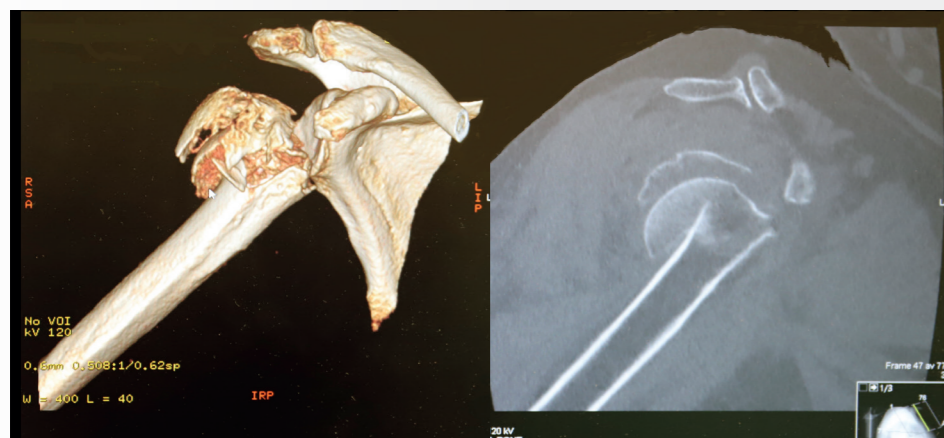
pre-op CT scanner 3D rendering (left) and sagittal view (right) of proximal humeral fracture
